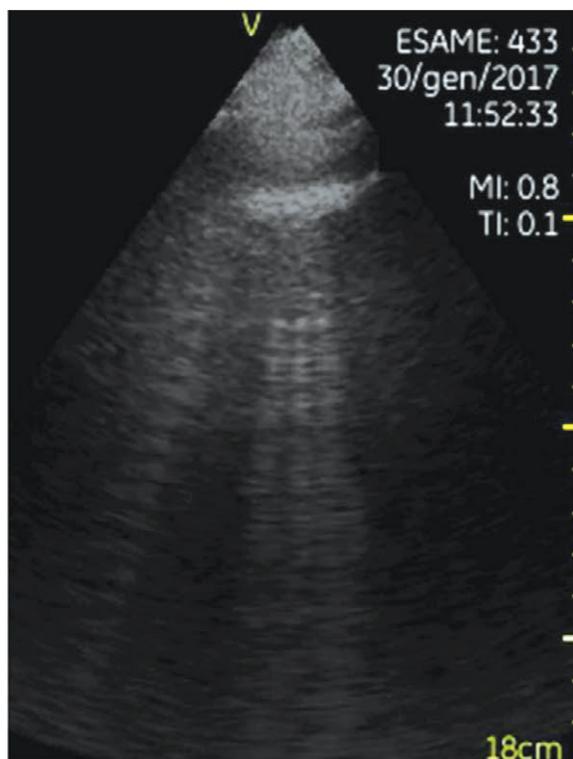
Case 1: Lung ultrasound (left lung) showing B-profile pattern-interstitial syndrome.
